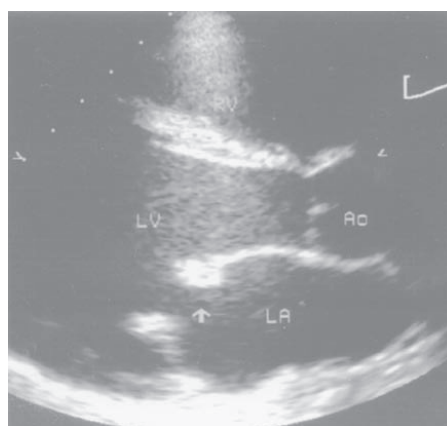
Two-dimensional echocardiogram obtained from parasternal long-axis in a patient with rheumatic mitral regurgitation. Focal thickening (nodule) on the tip of the anterior mitral leaflet is indicated by an arrow. LV: Left ventricle. LA: Left atrium. Ao: Aorta.
